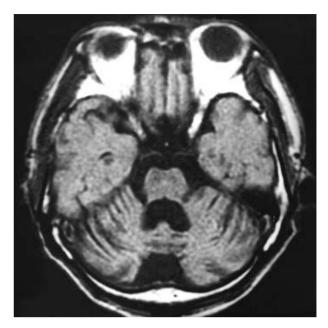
The axial view of T1-weighted brain MRI shows a marked atrophy of the cerebellar hemispheres and 4th ventricular dilatation.
